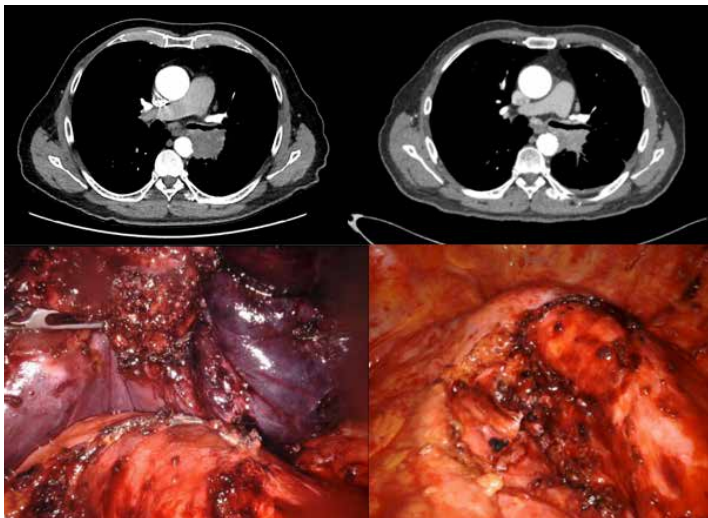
Preoperative CT Scan and intraoperative images showing the infiltration of the tumour into the aortic wall and intraoperative image after resection of the tumor
